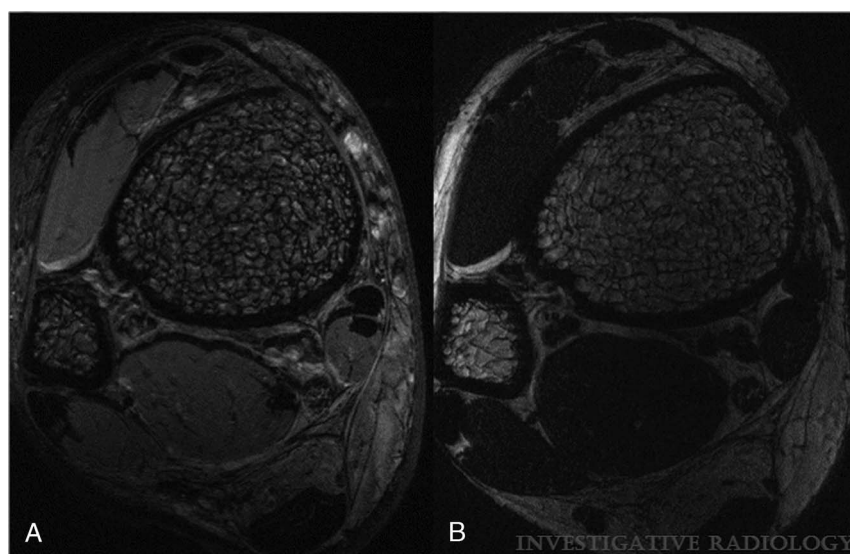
Magnetic resonance images of the distal tibia acquired in vivo with FIESTA-C at 7 T (A) and 3 T (B) are depicted. The enhanced visualization of trabecular bone structure at 7 T is well demonstrated by these images. Please note that, although the same sequence is used, chemical shift and susceptibility artifacts are enhanced at 7 T, shown by thicker appearing trabeculae and at the muscle/fat interface. Also, the image contrast and signal of muscle and fat are different at 7 T and 3 T. Reused with permission from Wolters Kluwer Health, Inc, Krug et al.⁹⁴
